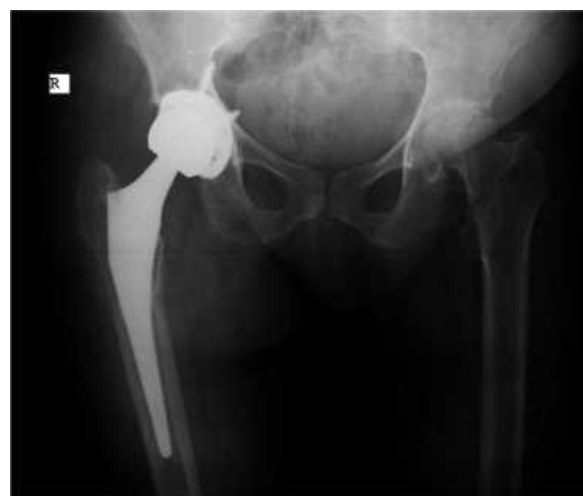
Pelvic X-ray [Anteroposterior (AP) view] after the first surgery showing degenerative changes in the left hip
